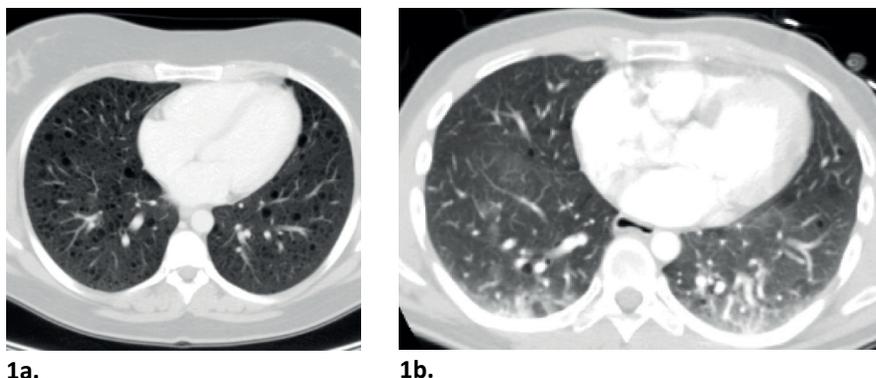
Two examples of CT findings of thin-walled pulmonary cysts in the lung bases consistent with lymphangioleiomyomatosis in patients with tuberous sclerosis complex
